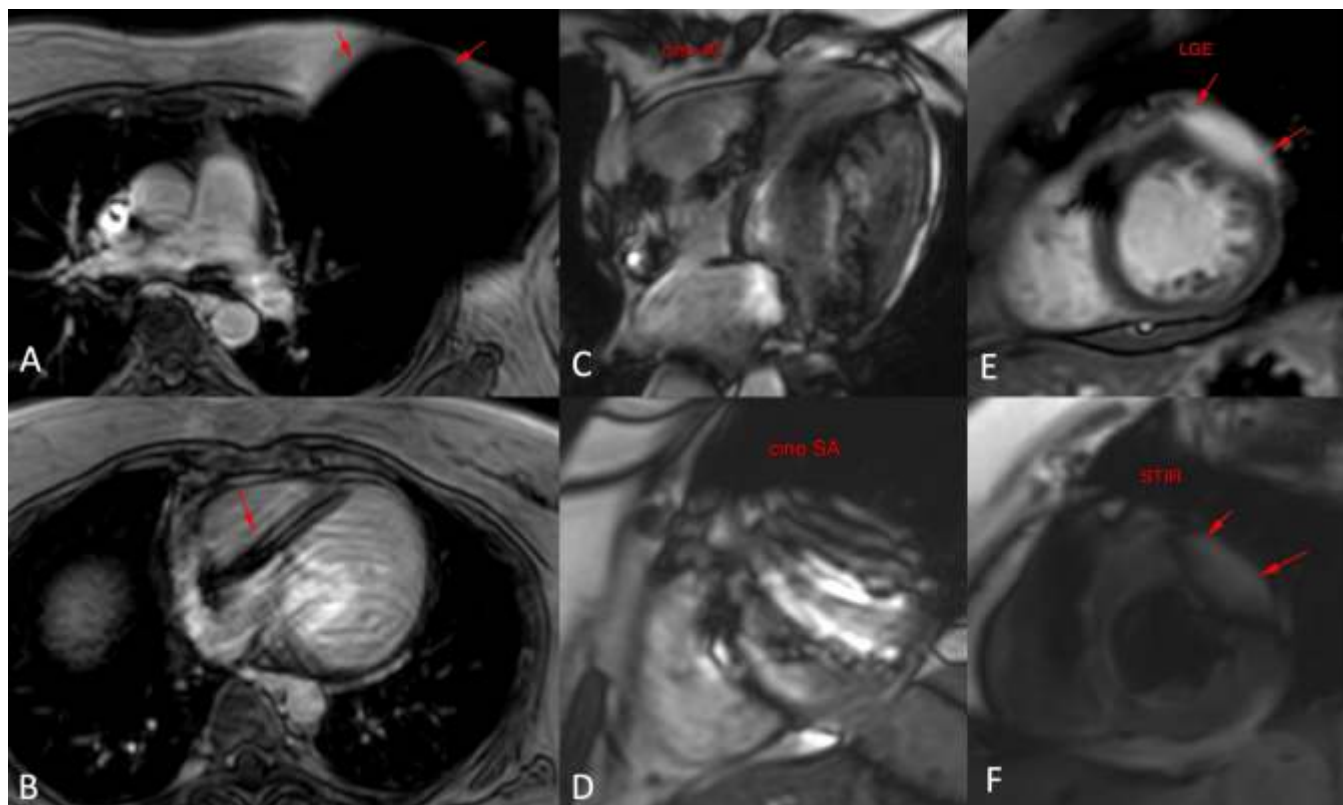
(A-F): 48-years old with cardiac sarcoidosis presented with worsening of symptoms. She had a pacemaker placed 3 years prior. Contrast enhanced images (A,B) show the pacemaker control unit (arrow in A) on the chest wall and the pacemaker lead in the right ventricle (RV) (arrow in B). There is degradation of image quality in the cine 4-chamber (C) and short axis (D) images, though it was possible to assess wall motion with moderate confidence. The short axis late gadolinium (LGE) image (E) however shows the abnormal enhancement in the basal anterior wall and anterolateral segment well (arrow) while the short axis STIR (F) image shows edema (arrow), both of which were new compared to an earlier 2020 MRI, suggesting acute exacerbation of inflammation and fibrosis.
